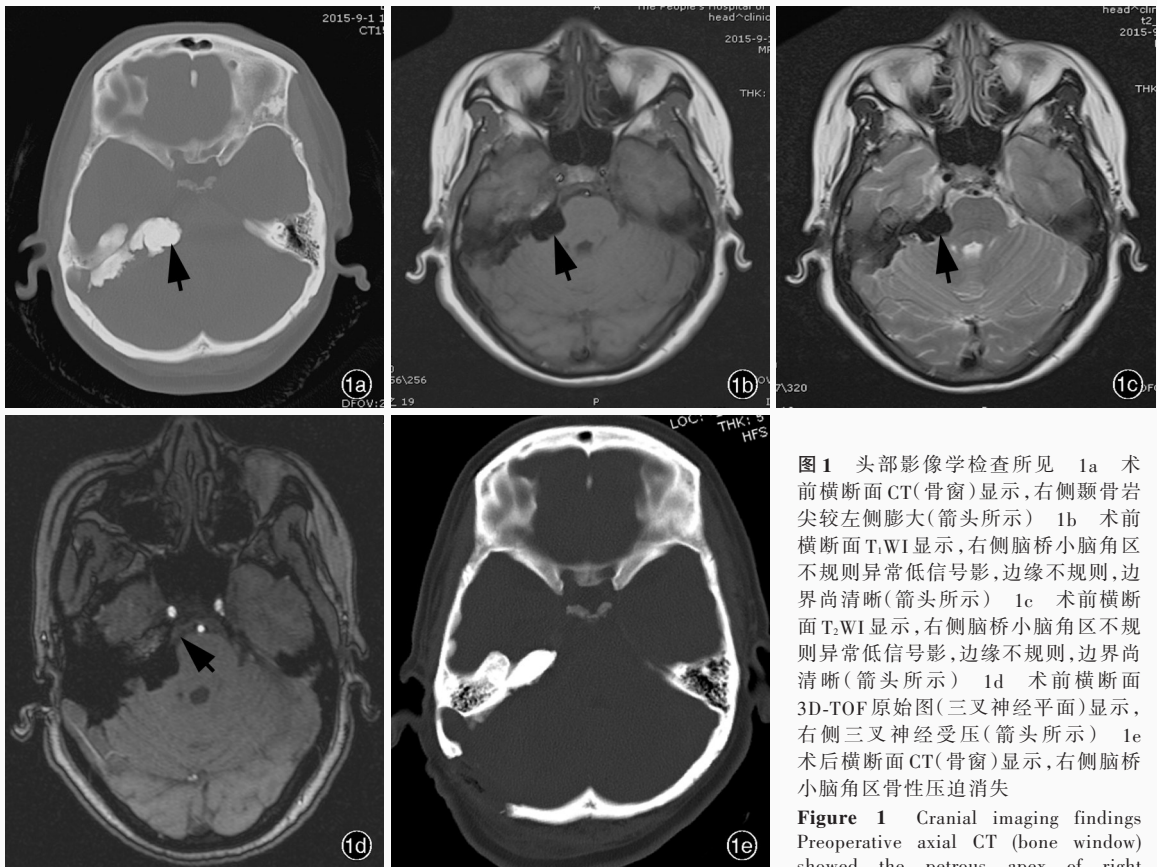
头部影像学检查所见 1a 术前横断面 CT(骨窗)显示,右侧颞骨岩尖较左侧膨大(箭头所示) 1b 术前横断面 T₁WI 显示,右侧脑桥小脑角区不规则异常低信号影,边缘不规则,边界尚清晰(箭头所示) 1c 术前横断面 T₂WI 显示,右侧脑桥小脑角区不规则异常低信号影,边缘不规则,边界尚清晰(箭头所示) 1d 术前横断面 3D-TOF 原始图(三叉神经平面)显示,右侧三叉神经受压(箭头所示) 1e 术后横断面 CT(骨窗)显示,右侧脑桥小脑角区骨性压迫消失
